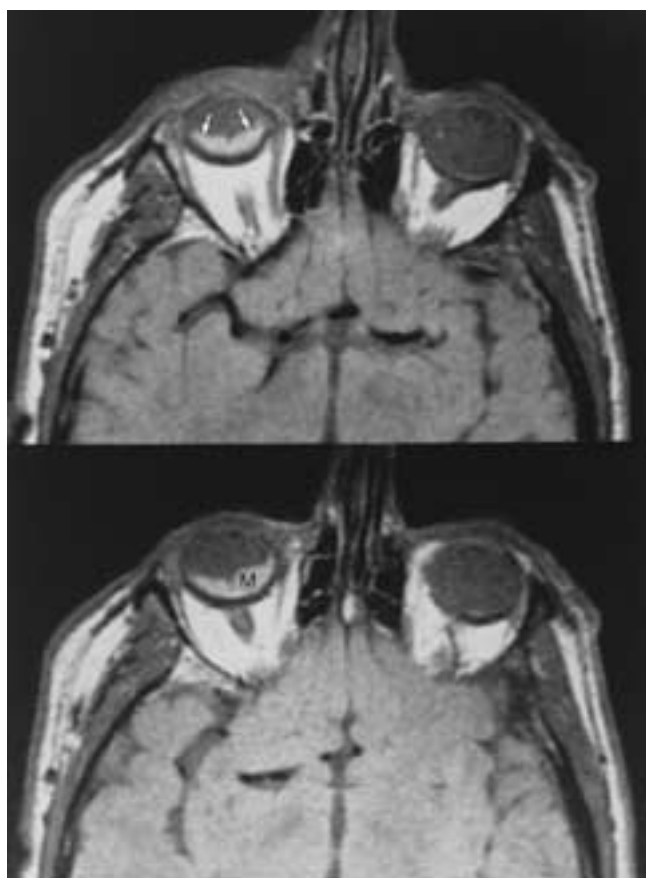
Retinal detachment caused by uveal melanoma. Axial PW MR images shows a mass (*M*) and exudative retinal detachment (*arrows*).
